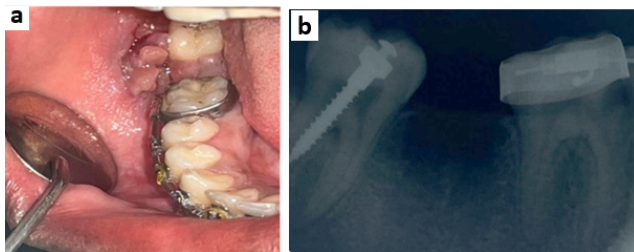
a): Tissue overgrowth in the right lower back buccal mucosa; b): Radiograph showing orthodontic bone screw placed in relation to 48.
